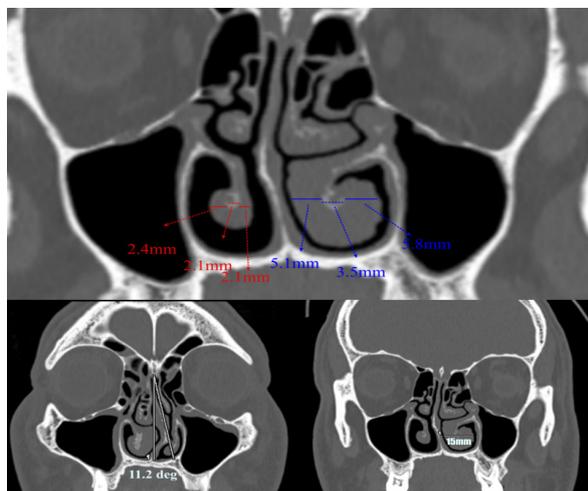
Coronal computed tomography section through the anterior portion of inferior turbinate showing measurement of medial, lateral mucosal thickness and bone thickness (top), measurement of septal deviation angle (bottom right) and total turbinate hypertrophy (bottom left)
